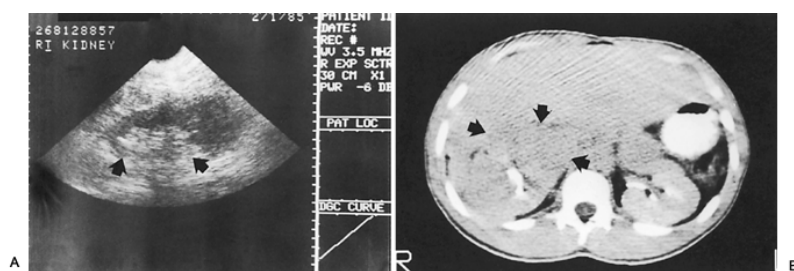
14. Longitudinal renal ultrasound (A) and computed tomography scan (B) demonstrating findings of a hypernephroma (arrows).
